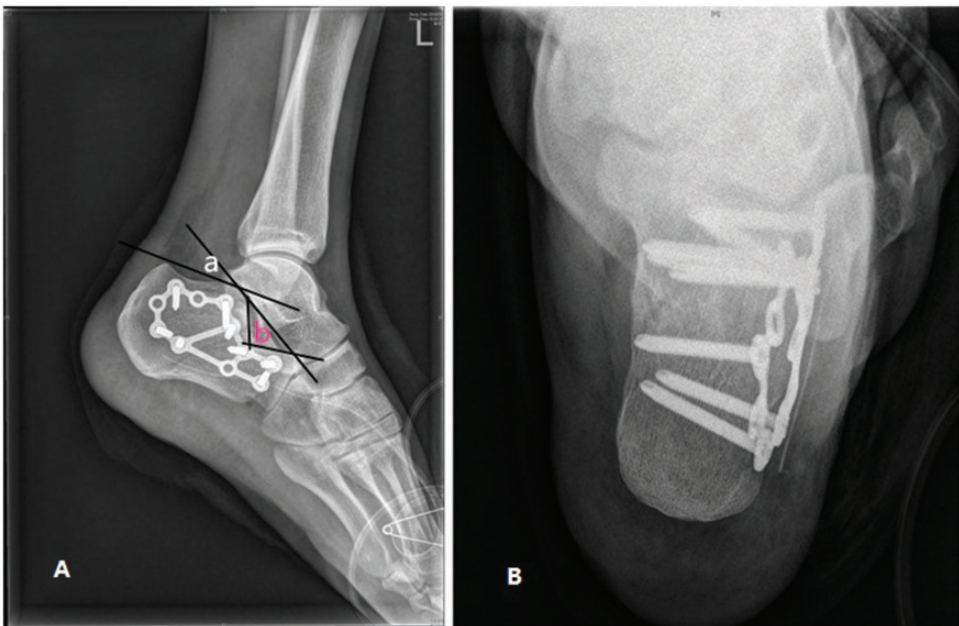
Postoperative lateral radiograph of the calcaneus shows anatomical reduction of the articular surface and correction of the Bohler angle and Gissane angle. Postoperative axial radiograph of the calcaneus shows satisfactory recovery of the calcaneus width.
